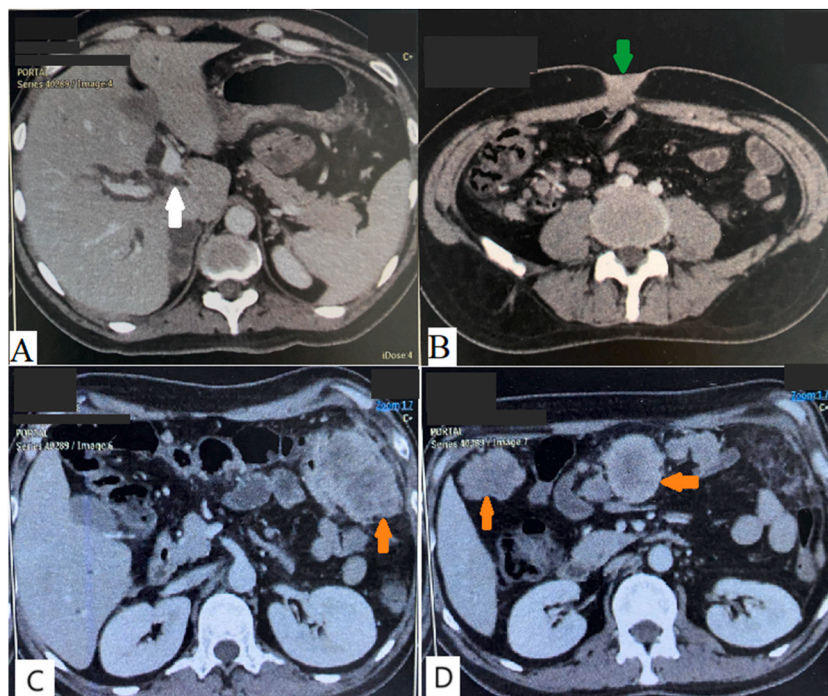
CT of the abdomen showing hilar cholangiocarcinoma extending to the superior biliary convergence (White arrow) (A). Umbilical nodule (Green arrow) (B). Peritoneal metastasis (Orange arrows) (C and D).
